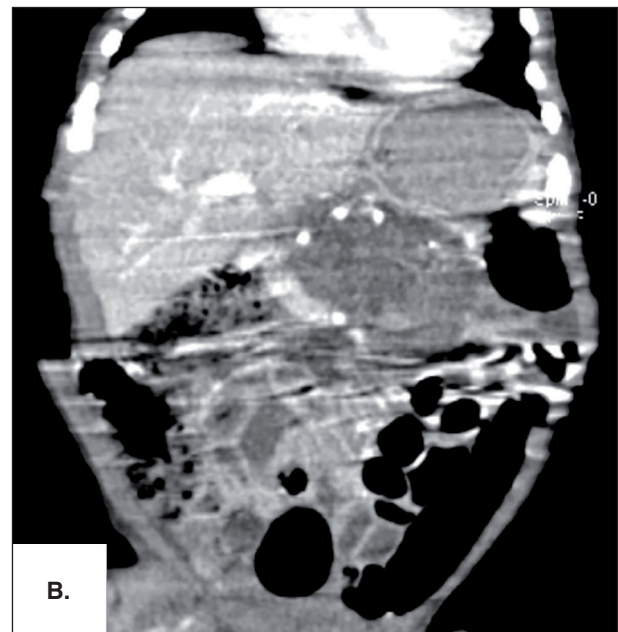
Abdominal computed tomography (CT) shows a 47 x 40 x 31 mm sized solid component and calcification containing mass, starting from the superior mesenteric artery level at the midline of the abdomen and extending to the left side (A. axial, B. coronal and C. sagittal sections).
